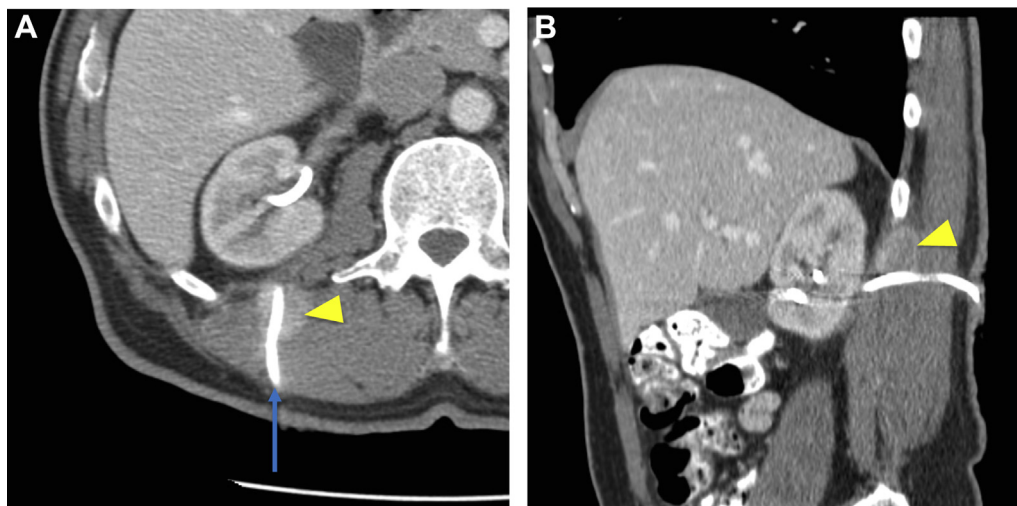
(A) Axial CT shows an enhancing 2 cm mass (yellow arrowhead) along the right percutaneous nephroureterostomy (blue arrow). (B) Sagittal reconstruction localizes the mass (yellow arrowhead) along the superior aspect of the percutaneous tract.
